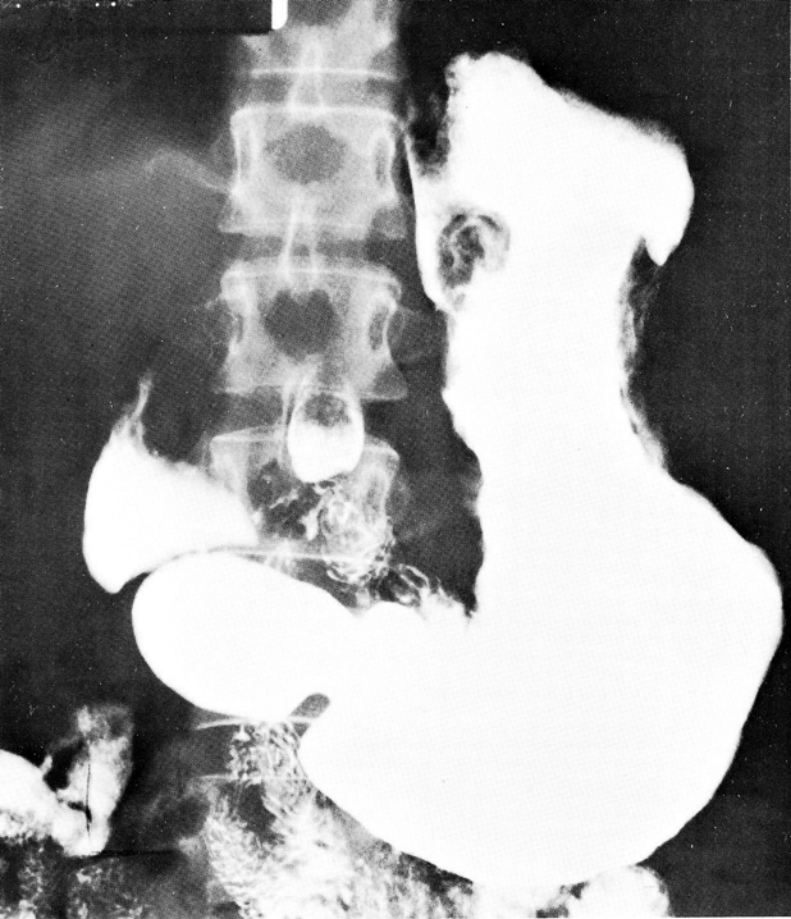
Roentgenogram of the stomach in April, 1962, showing infiltration of the lesser curvature and a nodule near the esophagus.
